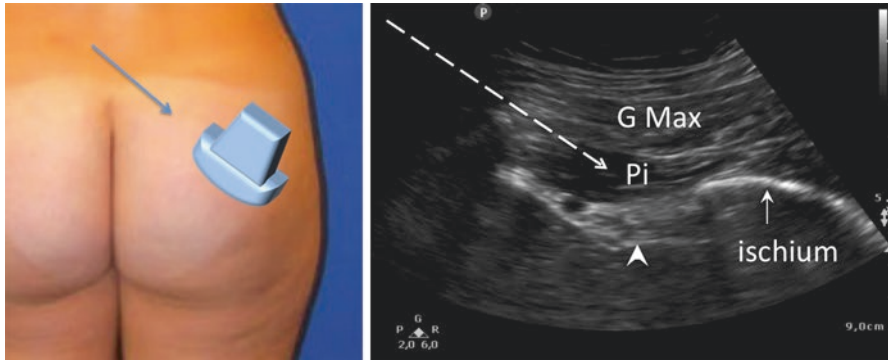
Left figure showing position of the needle and the probe and right figure showed the corresponding sonography. (Reprinted with permission from Philip Peng Educational Series)
